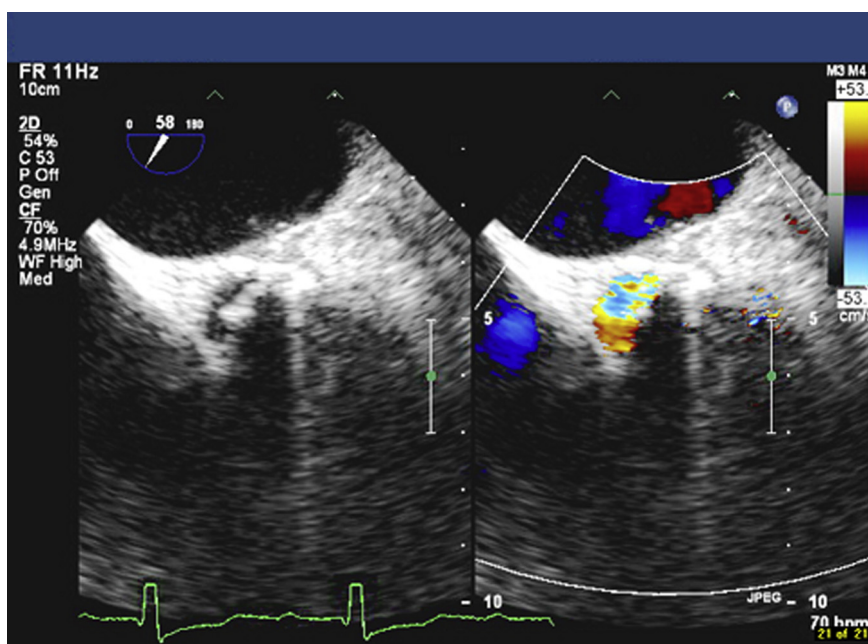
Transesophageal echocardiogram showing aortic paravalvular leak.
